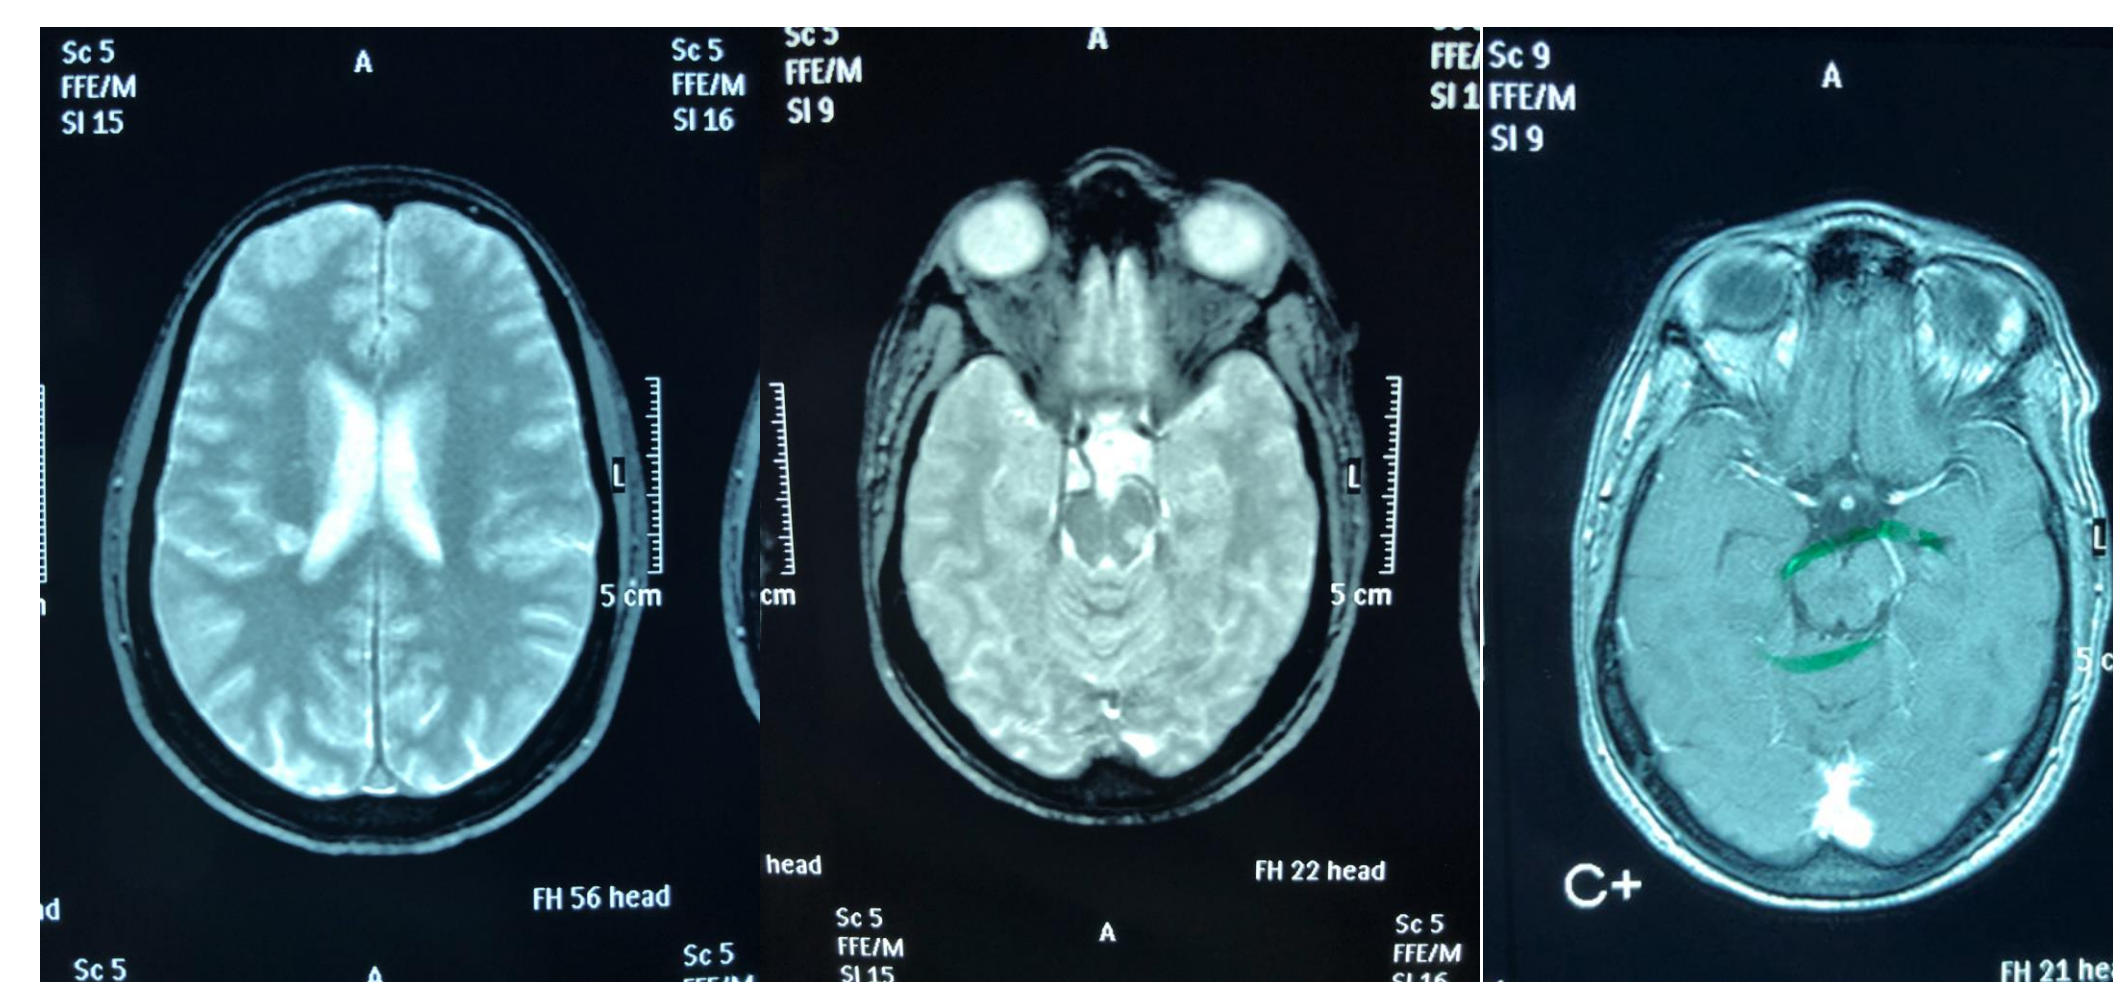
Left and middle image show the white matter changes on her diagnostic MRI. Image to the right demonstrates lesion presenting contrast enhancement.
